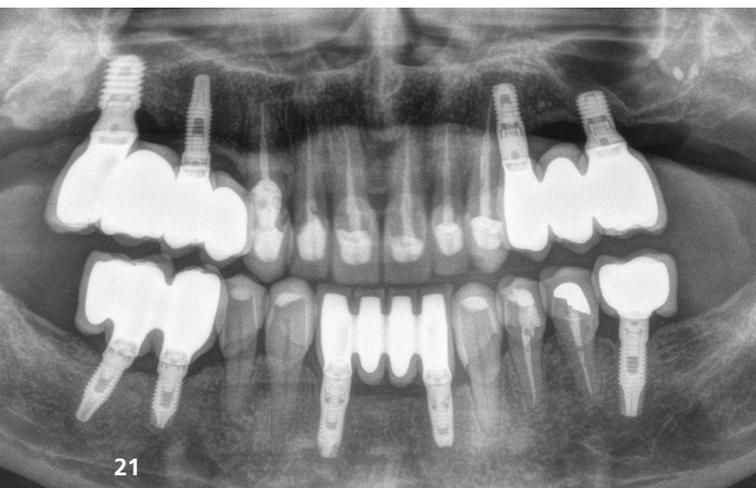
Final radiograph of the patient with the complete prostheses and the definitive crowns. Figs. 20 & 21: Initial and final radiograph at one year follow-up with total stability of the treatment achieved.
